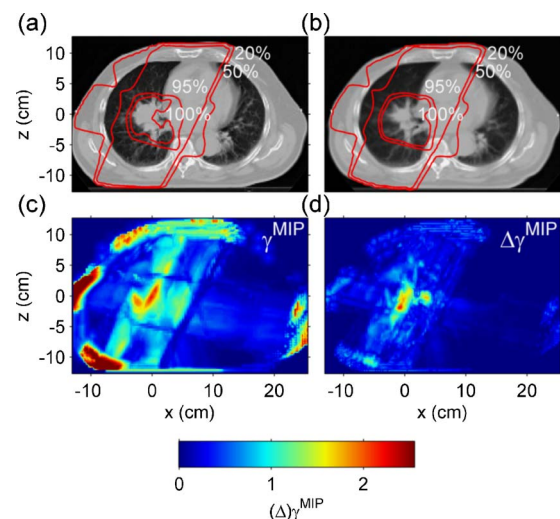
Axial CT slices (through the isocenter) from (a) the original planning CT scan and (b) a repeat CT scan of a lung cancer patient (example D). The 3D conformal treatment plan was calculated on every CT data set. Isodose lines, relative to the prescribed dose, are indicated. (c) Axial γ^{MIP} image (MIP, maximum intensity projection) from the 3D γ evaluation, 0.2 cm grid resolution and 0.02 cm sample step size. (d) Axial $\Delta\gamma^{\text{MIP}}$ image showing the difference between the axial 2.5D γ evaluation and the full 3D γ evaluation. Both MIP images were calculated from axial slices between 7 cm superiorly and 7 cm inferiorly around the isocenter.
